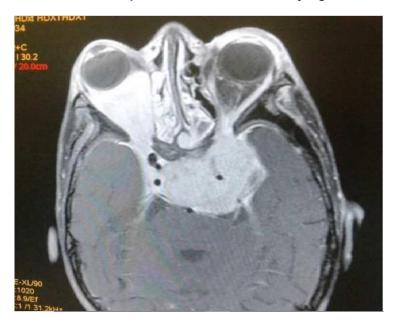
Case 2: MRI showing a voluminous tumoral process of the cavum locally advanced with endocranial extension
